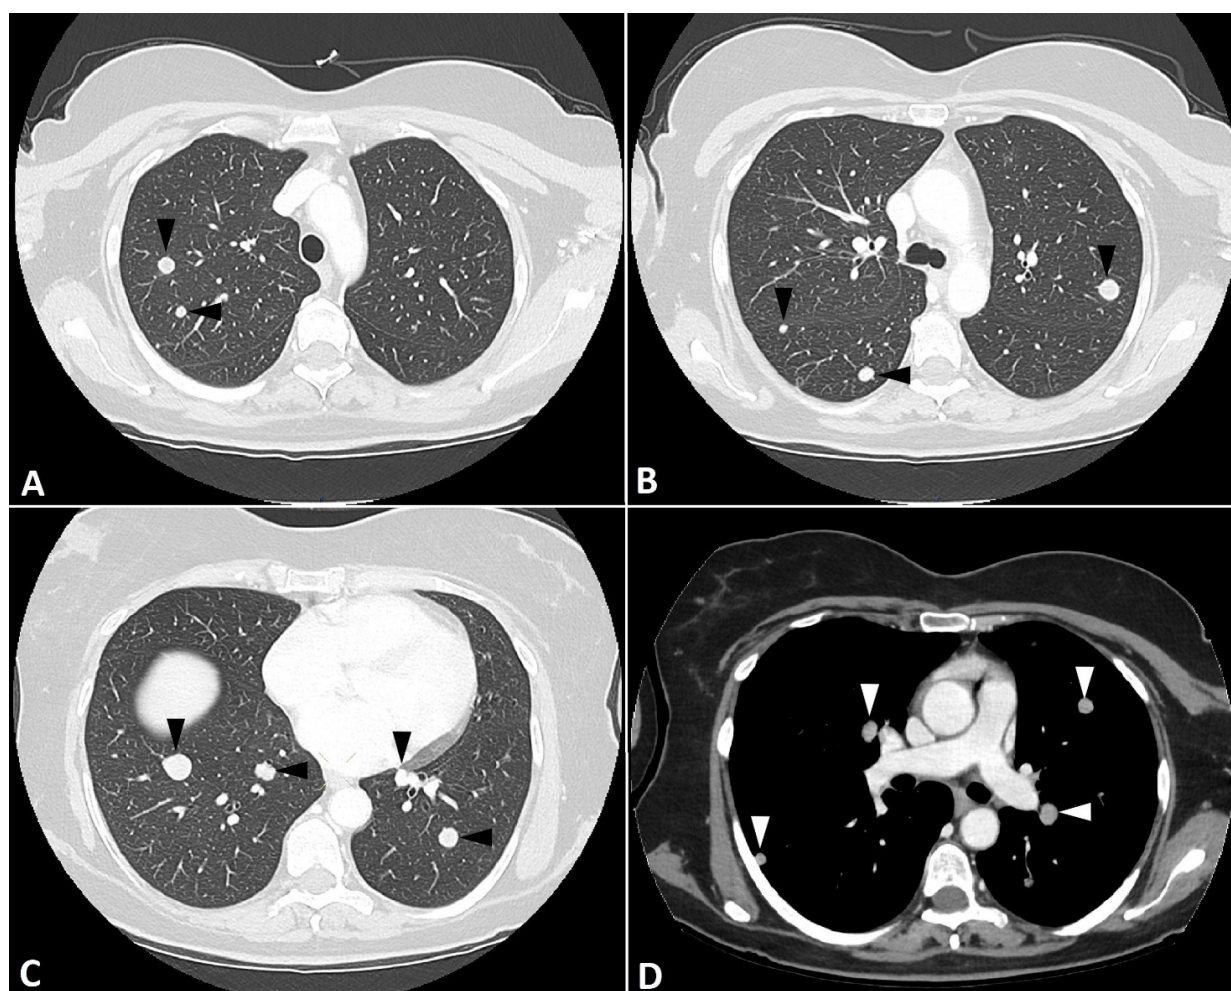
Metastasizing benign leiomyoma. (A–C) Chest computed tomography (CT) scan on axial plane of superior (A), medium (B) and lower lungs (C) of another patient affected by benign metastasizing leiomyoma, which shows multiple round nodules with clear margins (black arrowheads). (D) Chest CT scan on axial plane with contrast medium (venous phase) on the same patient: the soft tissue window highlights how the nodules have a fairly homogeneous contrast enhancement and no central necrosis (white arrowheads) and constitute a non-specific finding that is difficult to characterize with the CT imaging alone.
